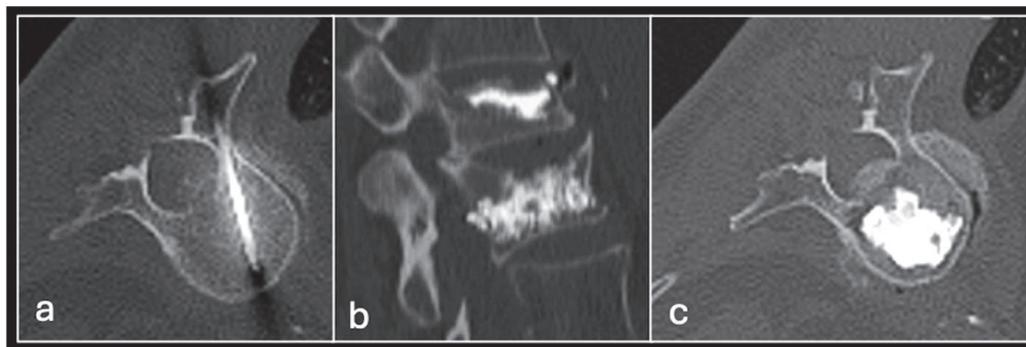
CT-guided vertebroplasty showing needle in the vertebral body (a) and sagittal (b) and axial (c) showing cement within the vertebral bodies.
